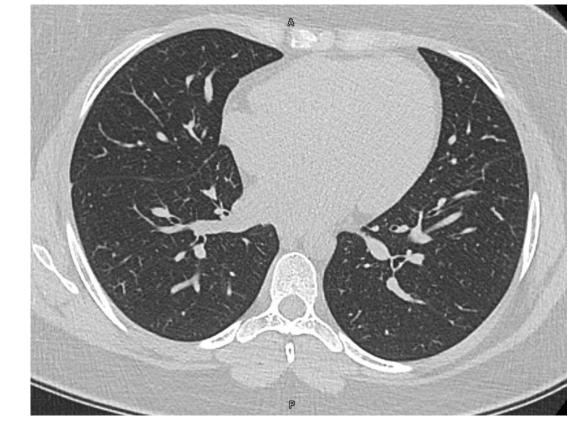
CT thorax showing radiologic resolution
